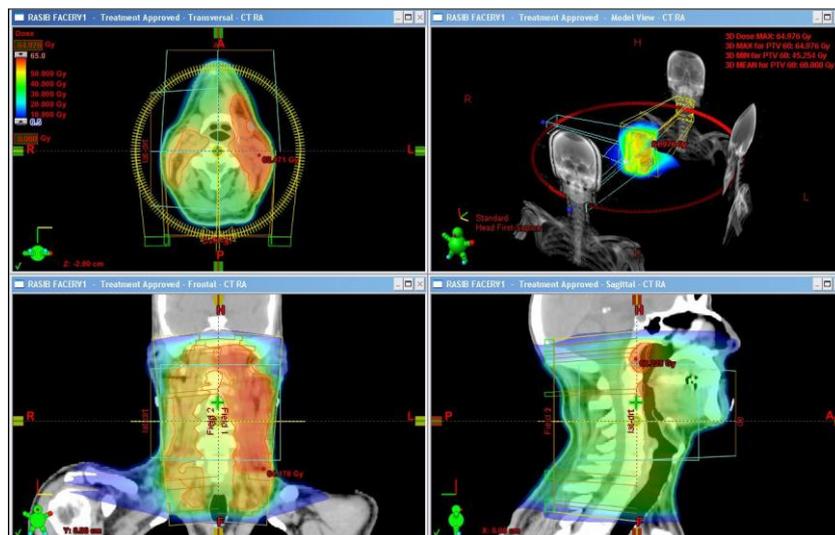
Planning CT showing dose distribution of head and neck, with VMAT technique.
